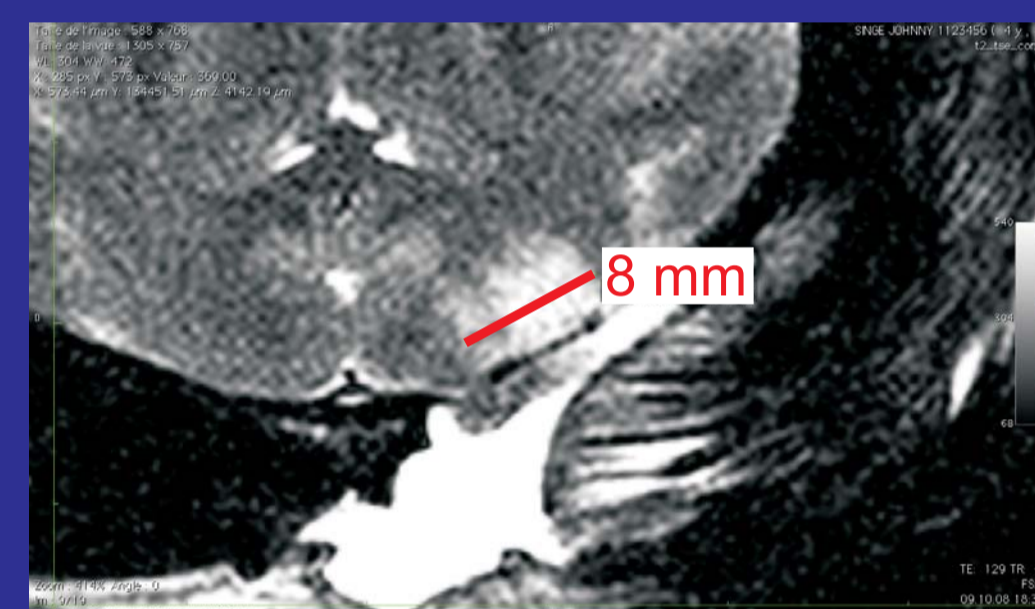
MRI showing the medio lateral extent of the lesion in Mk-CJ
